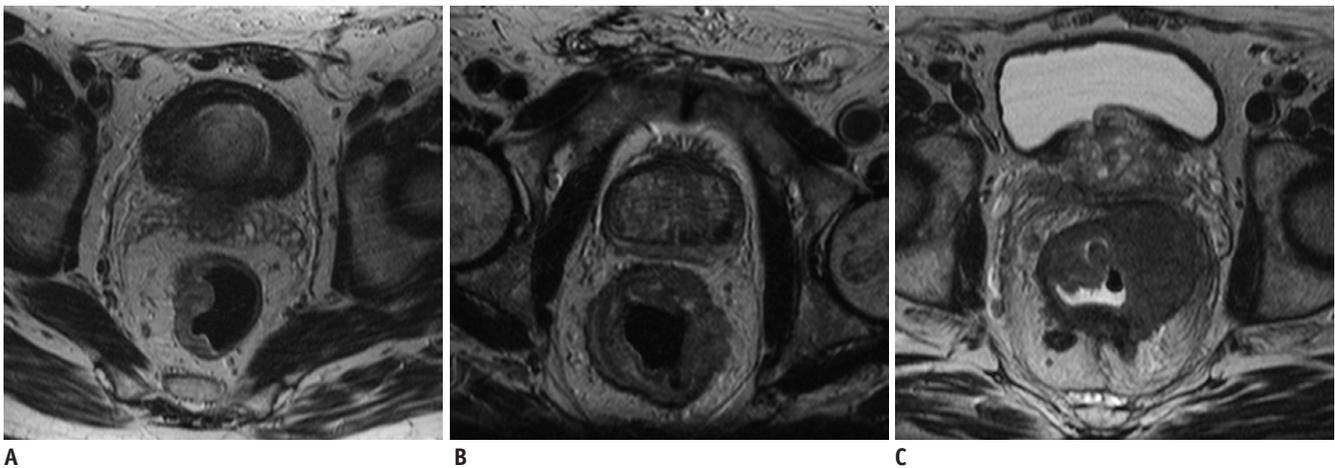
High-resolution Turbo Spin Echo T2-weighted axial scan of T3 rectal cancer in three different patients. In first patient (A) early T3 lesion is depicted with spiculations spreading through muscular layer into perirectal fat; lymph-node is located in mesorectum on right side. In second patient (B) MRI shows circumferential rectal mass with deep parietal infiltration spreading in perirectal fat tissue, without any involvement of CRM (> 2 mm). In third patient (C) axial scan shows large rectal mass with deep extra-mural neoplastic infiltration that involves mesorectal fascia both on anterior and left lateral side with positive CRM; some metastatic lymph nodes are depicted in mesorectal fat tissue. CRM = circumferential resection margin
